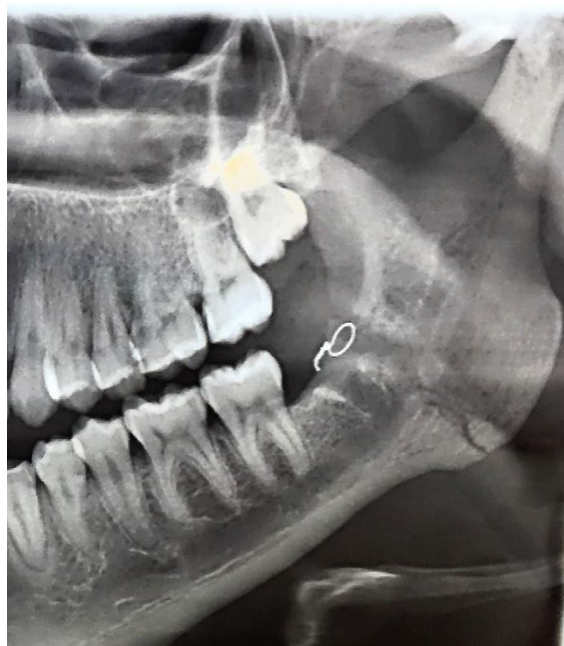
An immediate post-operative radiograph of patient 3 showing the right mandibular angle fracture reduced using a superior border miniplate.
